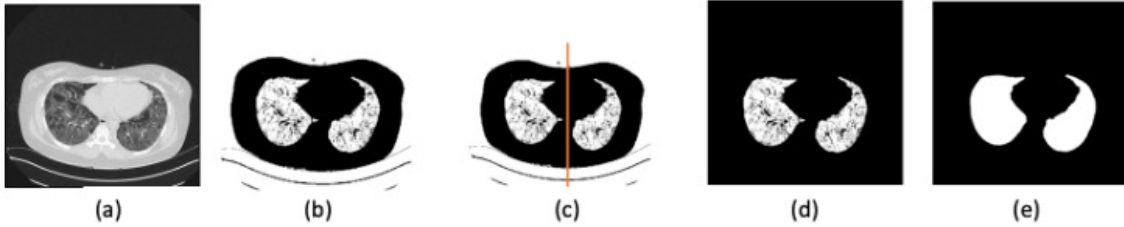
Sequence of steps for lung parenchyma extraction. (a) CT image; (b) Threshold with Otsu; (c) Vertical cut in the center of the image resulting from the Otsu algorithm, generating two new images; (d) Selection of the second largest region in the two images generated in the previous step; (e) Result after application of morphological operations.
